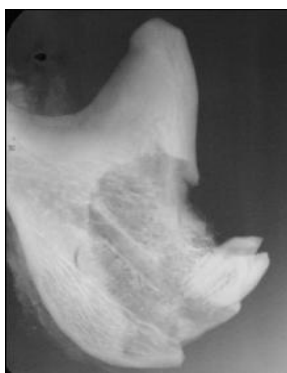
Post-mortem radiograph of the fragment of the right mandibular ramus.
